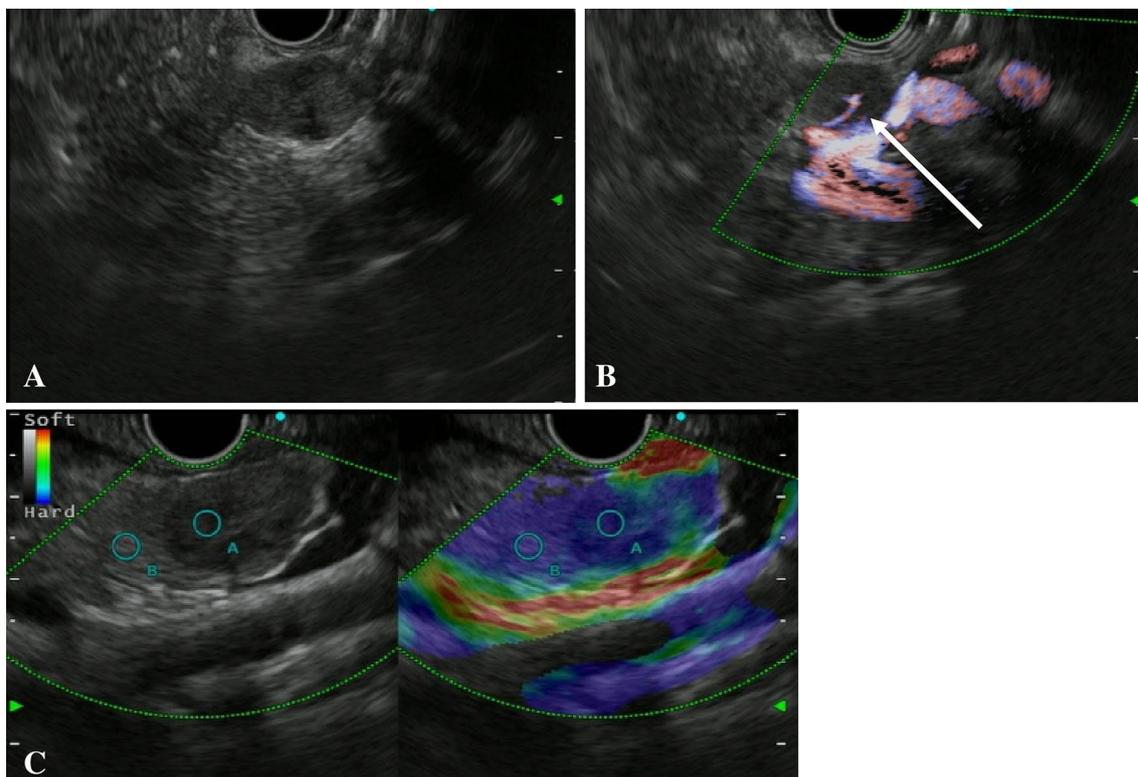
Endoscopic ultrasonography of the tumor. a The tumor shows a homogenous, well-defined hypoechoic mass measuring 16×10 mm in size in the pancreatic body with posterior hyperechoic shadow. b
